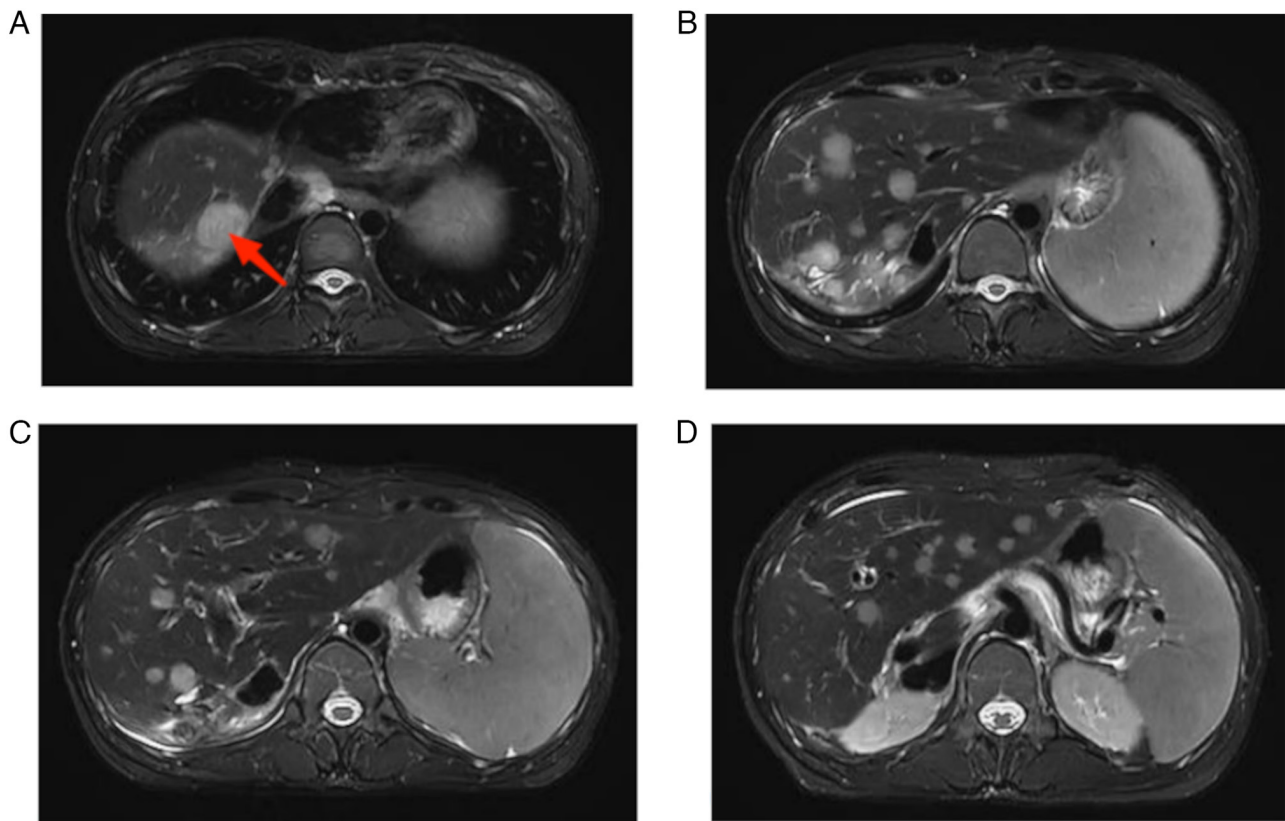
MRI T2-weighted imaging. Multiple metastases (high signal intensity) are visible in the hepatic parenchyma. The lesions significantly increased in number and size three months after the time-point of Fig. 1. (A) The largest one is located in the dome of the right hepatic lobe (red arrow) and measures ~2.8 cm in diameter. (B) There are numerous metastatic foci identified in liver segment SII, SVII, and SVIII. (C) Multiple metastatic foci are observed at the junction of SII and SIII, SV and SIV, as well as SVII and SVIII within the liver segment. (D) A significant number of metastatic foci are present in SII and SIV of the liver segment.
